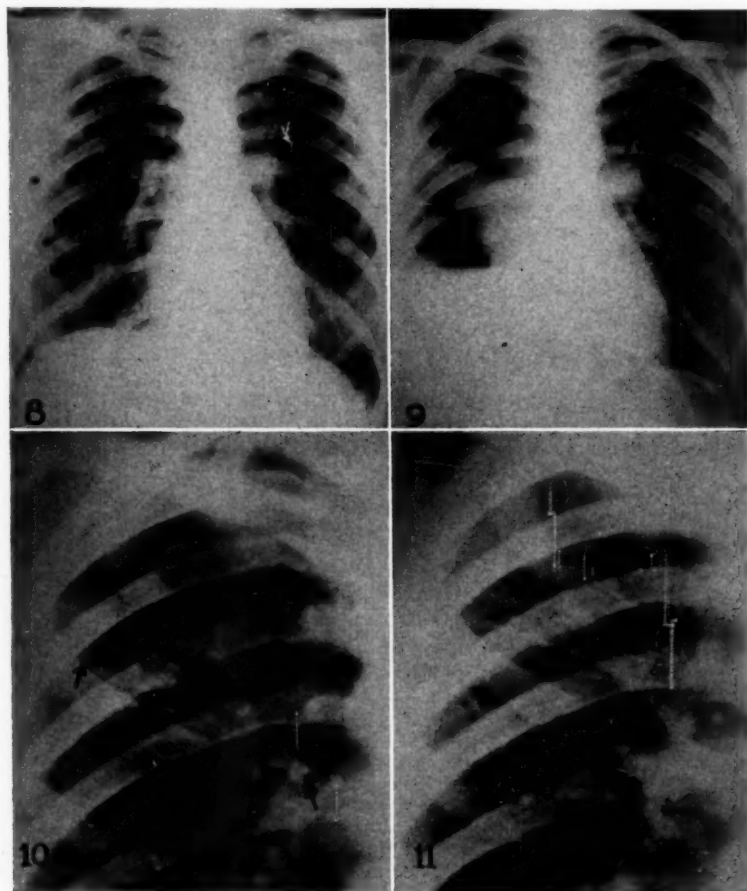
Case 4. Roentgenogram of normal chest taken April 16, 1936.
